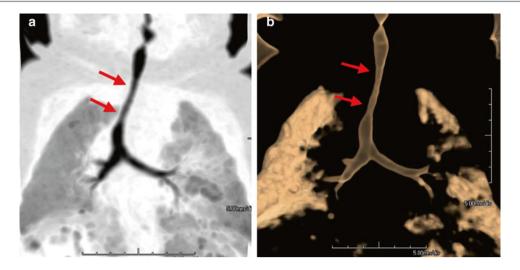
Coronal minimum intensity projection image (MinIP) (a) and 3D volume rendered image (b) from an airway CT show an approximately 2 cm-long concentric stenosis (*arrows*) of the trachea. At bronchoscopy, complete tracheal rings were identified
